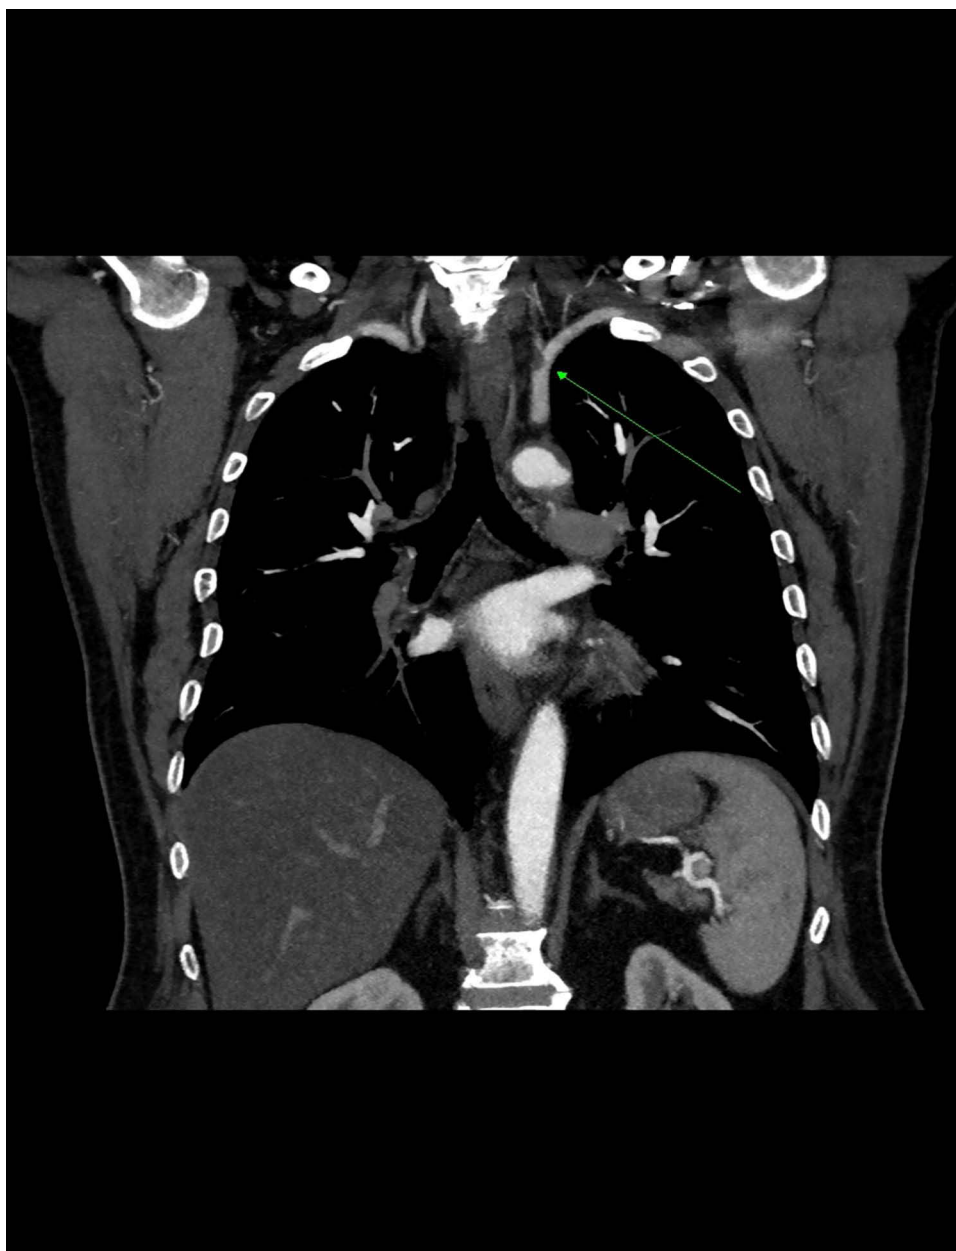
Coronal view of CT angiography indicating left subclavian stenosis at the origin (by arrow).
